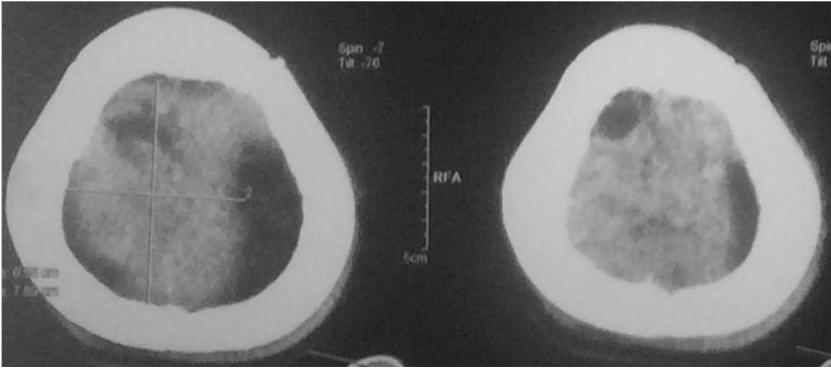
Axial view of brain CT Scan showing a hyperdense lesion in the vertex region indicating acute hemorrhage
